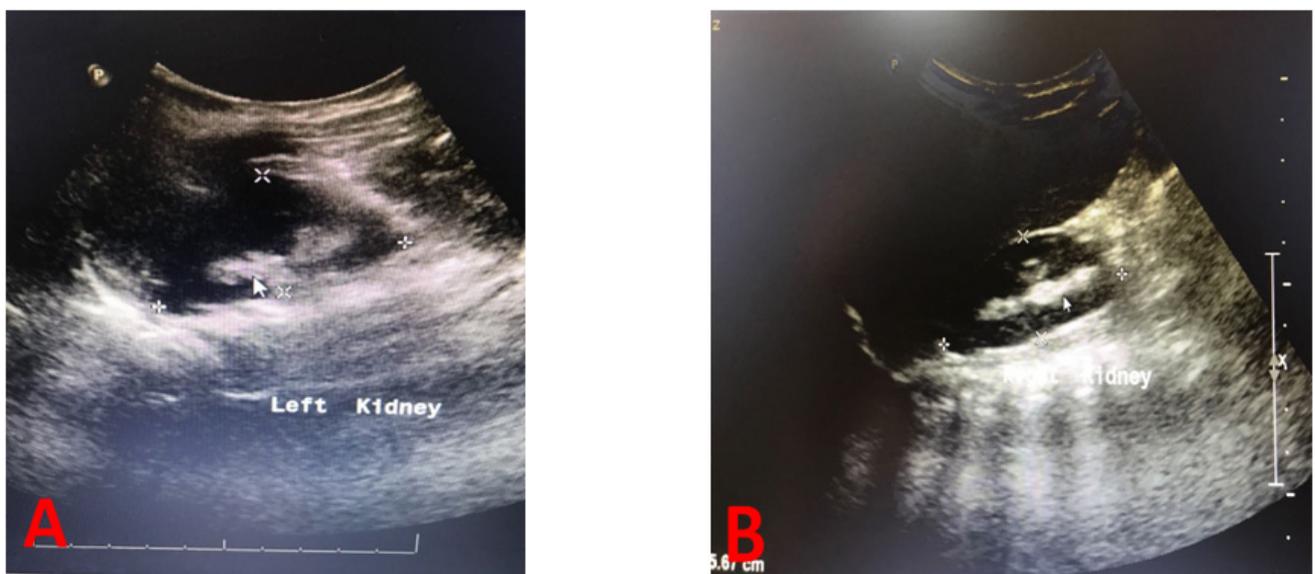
Renal Ultrasound. (A) Left kidney; (B) Right kidney, both showed multiple bilateral renal stones
